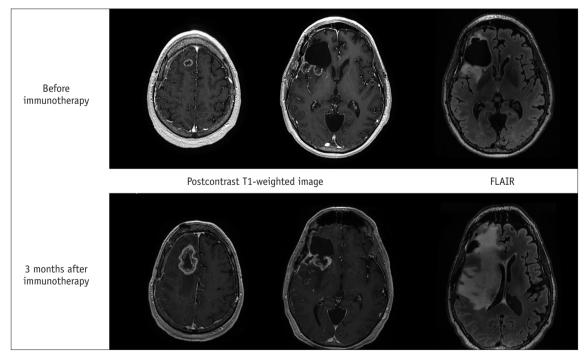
A 64-year-old male with recurrent glioblastoma shows heterogeneous enhancing masses with perilesional edema at the posterior resection margin and in the right superior frontal gyrus. MRIs obtained 3 months after immunotherapy demonstrate marked enlargement of enhancing lesions with progression of edema, suggesting pseudoprogression. FLAIR = fluid-attenuated inversion-recovery
